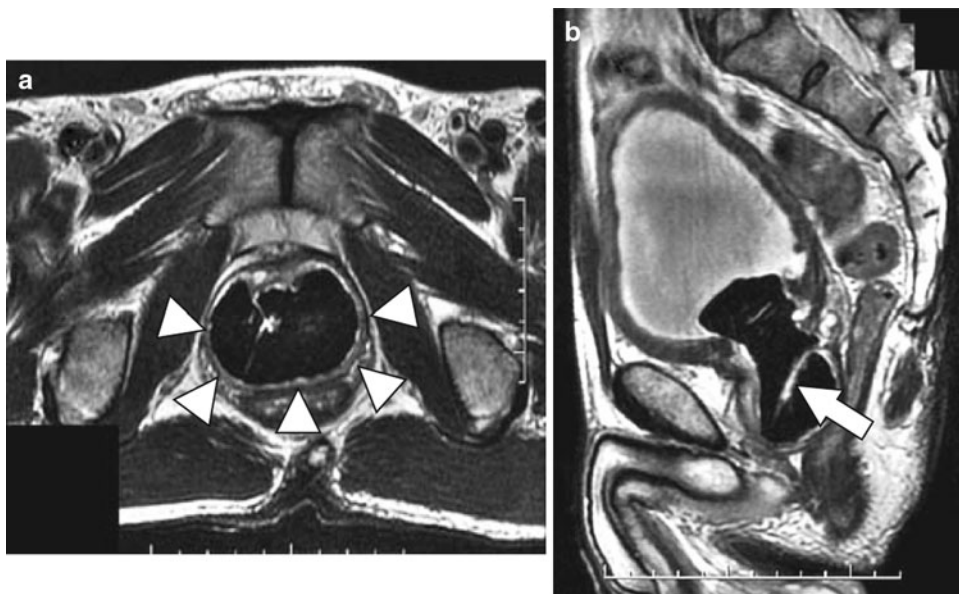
MRI showed a thin prostatic tissue (arrowhead) around the calculus and an ejaculatory duct (arrow)
